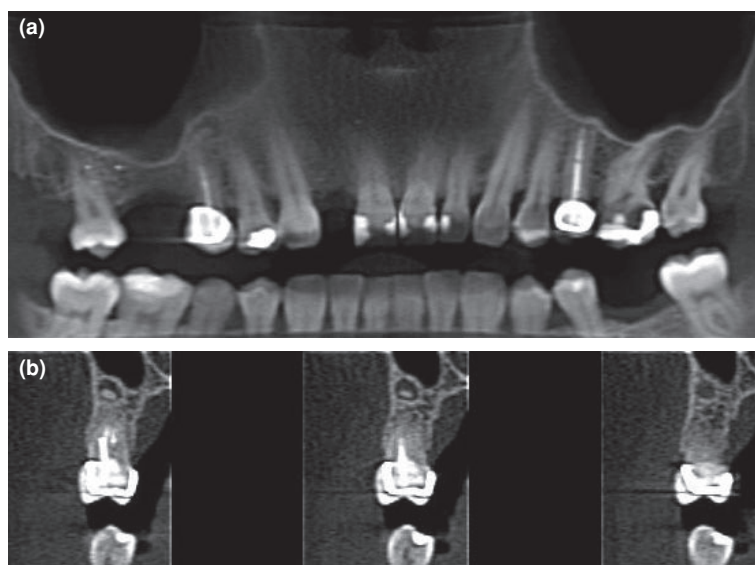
(a) Panoramic (b) coronal CBCT views. Tooth 15 has a failing endodontic treatment, and has been scheduled for periapical microsurgery. The CBCT scan is helpful in this situation as it provides vital information on the extent of the periapical lesion and its proximity to the floor of the maxillary sinus.
